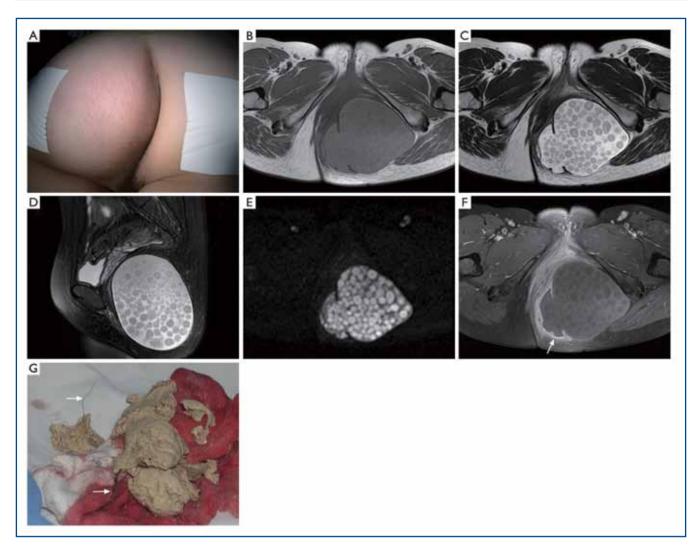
A 30-year-old female with left hip swelling and pain for 2 weeks. A: Clinical photograph shows the left hip is red swelling; B: Axial gradient echo T1 weighted MR image demonstrates a heart-shaped mass in the left buttock containing multiple hypo- and slightly hyperintense nodules; C: Axial fast spin echo T2 weighted image shows multiple "pomegranate seeds" with a hyperintense center against the background of liquid signal; D: Sagital fat-saturated fast spin echo T2 weighted image reveals no significant signal suppression of those nodules and no relationship between the mass and sacrum, coccyx or the rectum; E: Echo planar diffusion weighted image shows hyperintensity of the nodules, indicating restricted water molecular diffusion within them; F: Contrast enhanced gradient echo T1 weighted image shows remarkable enhancement of the cystic wall (arrow) without any enhancement of the nodules; G: Yellow sebum-like materials with hairs (arrows) taken out from the cystic mass.
